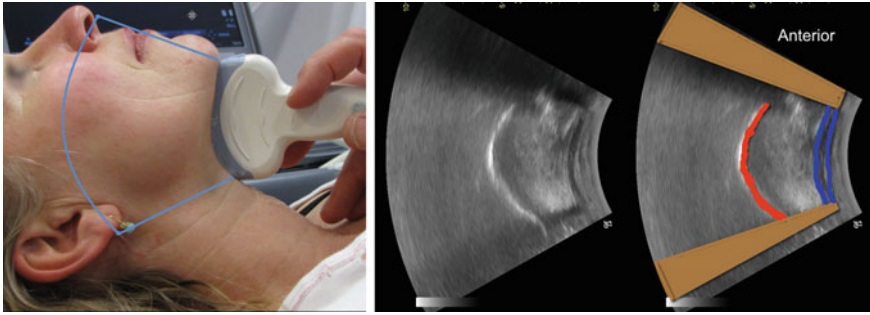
From the tip of the tongue to the hyoid bone. *Left* The light blue marking indicates the scanning area. *Middle* Ultrasonographic image. *Right* Brown indicates the shadow from the mandible anteriorly and from the hyoid bone posteriorly; the red line indicates the surface of the tongue; blue is base of the floor of the mouth
